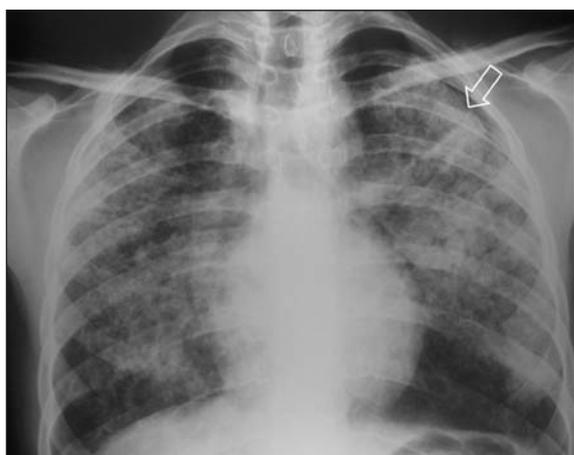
Posteroanterior chest X-ray of 1<sup>st</sup> case: Bilateral reticulonodular densities and minimal pneumothorax.
